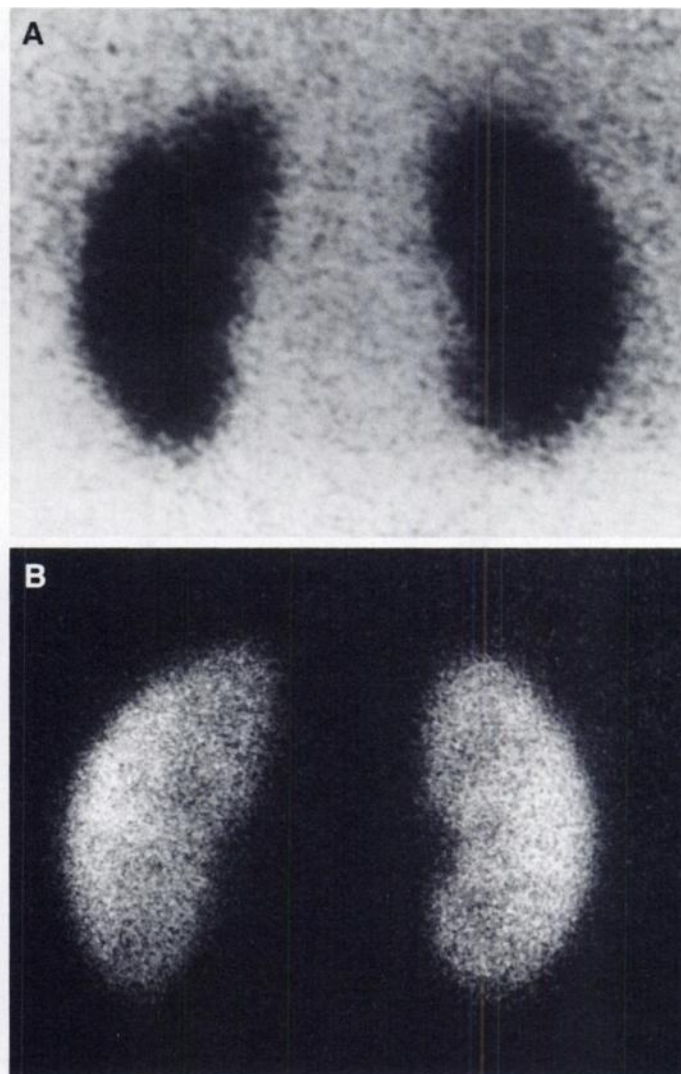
Grade 2 lesion in the left upper pole identified in the (A) MAG3 study was not identified by (B) GH scintigraphy.
